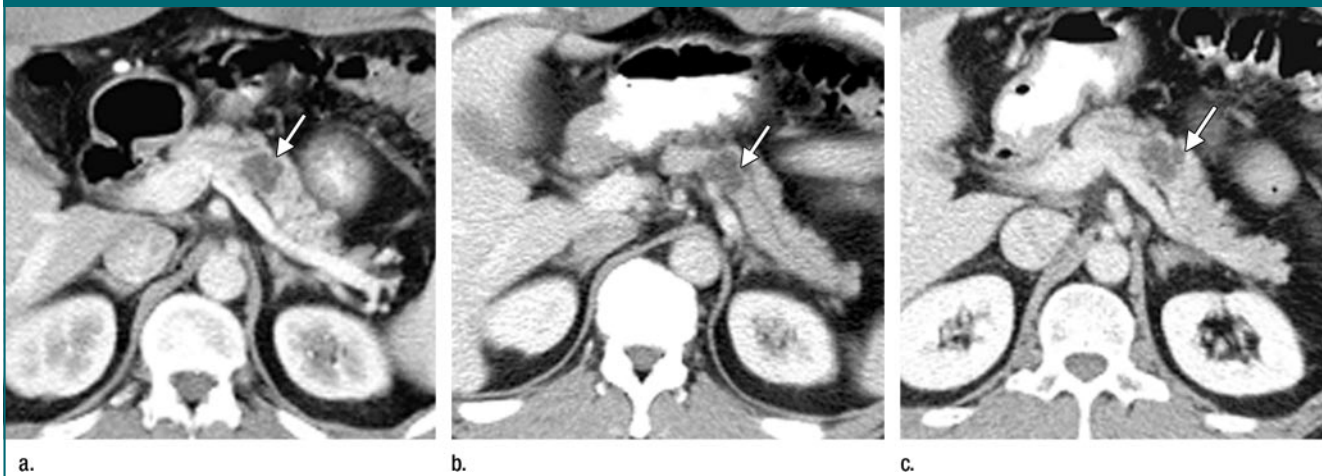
(a–c) Serial transverse contrast-enhanced CT images of abdomen in 69-year-old man. A 2.7-cm intraductal papillary mucinous neoplasm (arrow) involving the body of the pancreas was confirmed at endoscopic US–guided aspiration and biopsy and remained unchanged during the 2-year follow-up.
